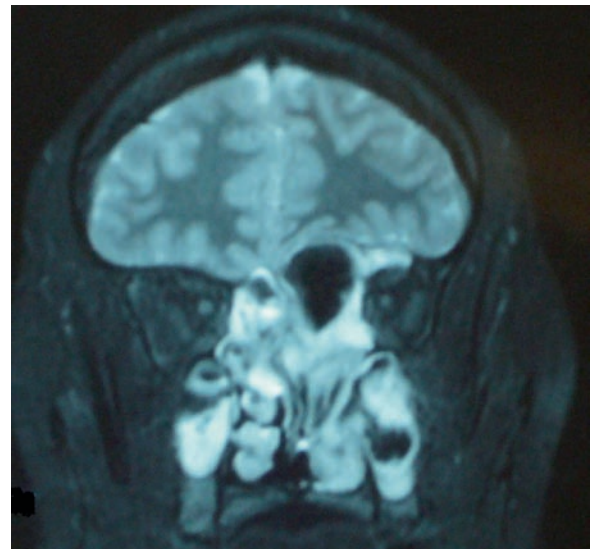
T2-weighted coronal MR image with STIR fat suppression in a patient with AFS. Note the signal void in the left maxillary sinus and the expanded left posterior ethmoid cell with intracranial expansion. The signal void in this ethmoid cell is caused by allergic mucin with high protein and low water content
